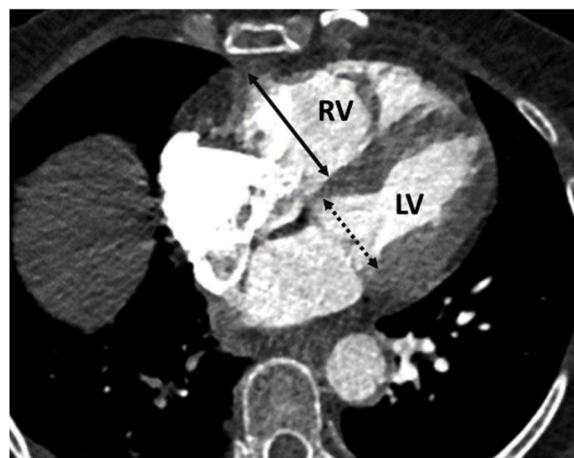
Measurement of RV and LV diameter on axial CTPA image. The ventricular diameters were determined by identifying the maximum distance perpendicular to the long axis of the heart between the ventricular endocardium and the interventricular septum. The RV/LV ratio was then calculated. (CTPA: Computed tomography pulmonary angiography; RV: right ventricle; LV: left ventricle).
